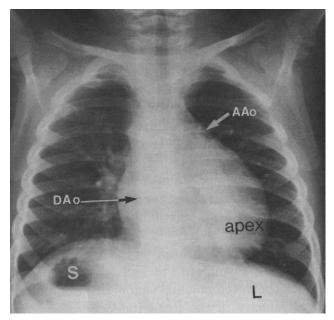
X-ray from a 2-year-old female infant in situs inversus with a left thoracic heart. The stomach (S) is on the right, the liver (L) is on the left, the heart is on the left, and the left hemidiaphragm is lower than the right hemidiaphragm. The descending thoracic aorta (DAo) is on the right, but the ascending aorta (AAo) is discordant. Reproduced with permission from Perloff JK. *The Clinical Recognition of Congenital Heart Disease*. 5th ed. Philadelphia, Pennsylvania: W.B. Saunders, 2003.
